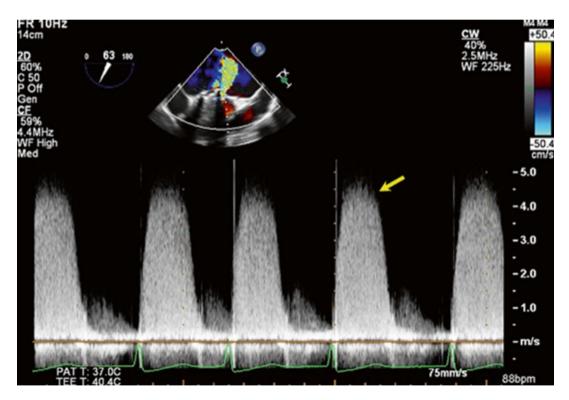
2D TEE continuous-wave Doppler, status post MV replacement, high-pressure-gradient mitral paravalvular leakage (*arrow*) was present
